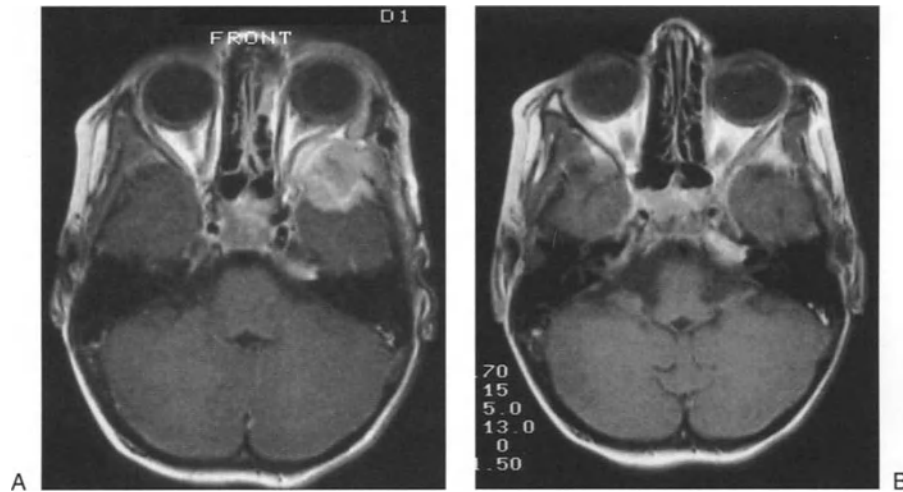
Rhabdomyosarcoma* is the most malignant tumor of the orbital adnexa. Seldom are these tumors operable, except when a total orbital exenteration is possible, but they do respond favorably to chemotherapy. (A) An axial MRI scan
